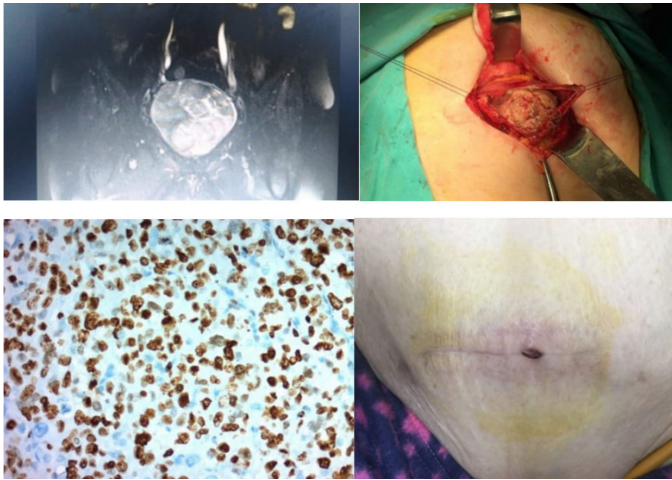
Magnetic resonance imaging of the mass, 1b. Mass in the bladder, 1c. Anti-Ki-67 antibody (30-9, Ventana, USA; ×20) positivity in over 75% of tumor cells, 1d. Fistula to suprapubic incision scar
